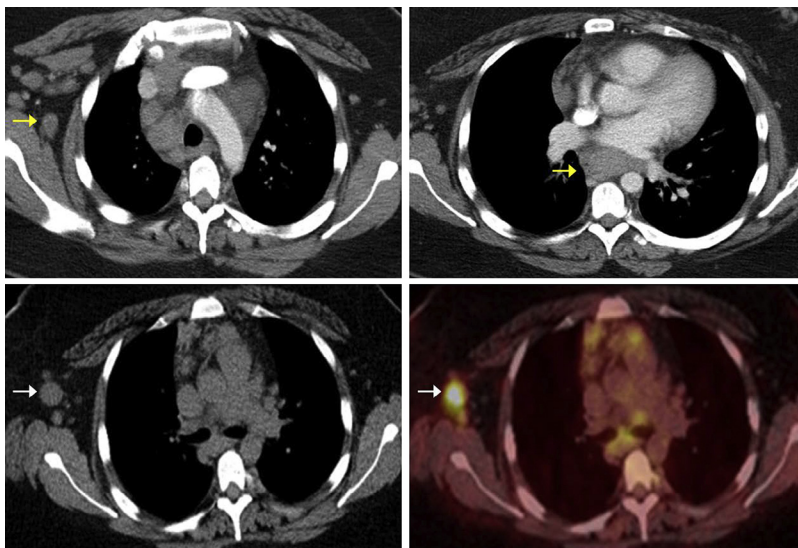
PET computed tomography scan of the chest/abdomen/pelvis demonstrates bulky mediastinal and axillary lymphadenopathy (arrows).
